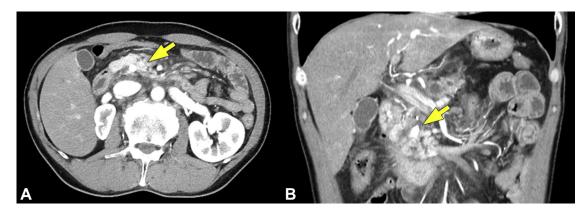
Enhanced CT abdominal image (A, axial; B, coronal) showing impacted stone in pancreatic head with tail-side dilation of main pancreatic duct. The stone is 16 mm in maximum diameter. Pancreatic parenchyma is swelling with an increase in soft tissue density circumference of pancreas.
